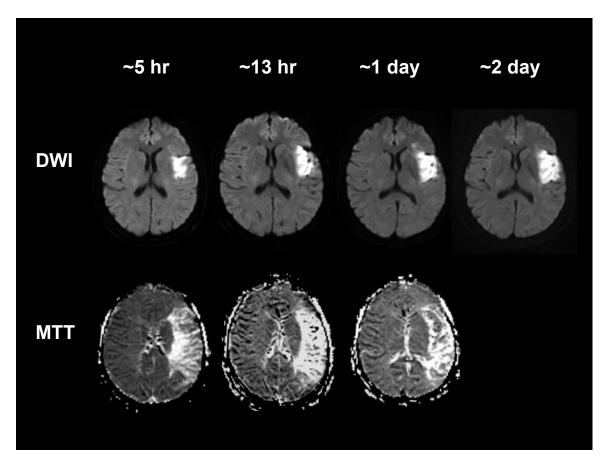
Diffusion and perfusion images of patient with a left MCA mainstem occlusion that persisted at 24 hours. Diffusion/perfusion MRI was performed at ~5 hours, ~13 hours, ~1 day and ~2 days from last seen well.
